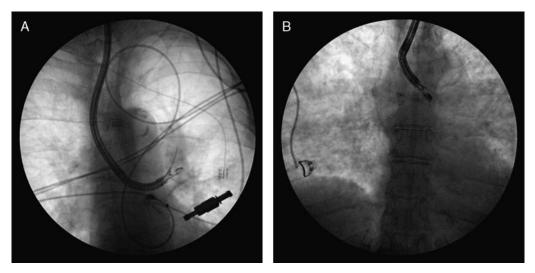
A, Fluoroscopic image of EBUS-TBNA of a lung lesion in the territory of lymph node station 5. The dedicated needle was used to obtain adequate cytology samples for diagnosis of non-small cell lung cancer. In contrast, (B) shows the fluoroscopic image of EBUS-TBNA of lymph node 4 L adjacent to the aorta and pulmonary artery, but in close proximity to the lower paratracheal space. EBUS indicates endobronchial ultrasound; TBNA, transbronchial needle aspiration.
